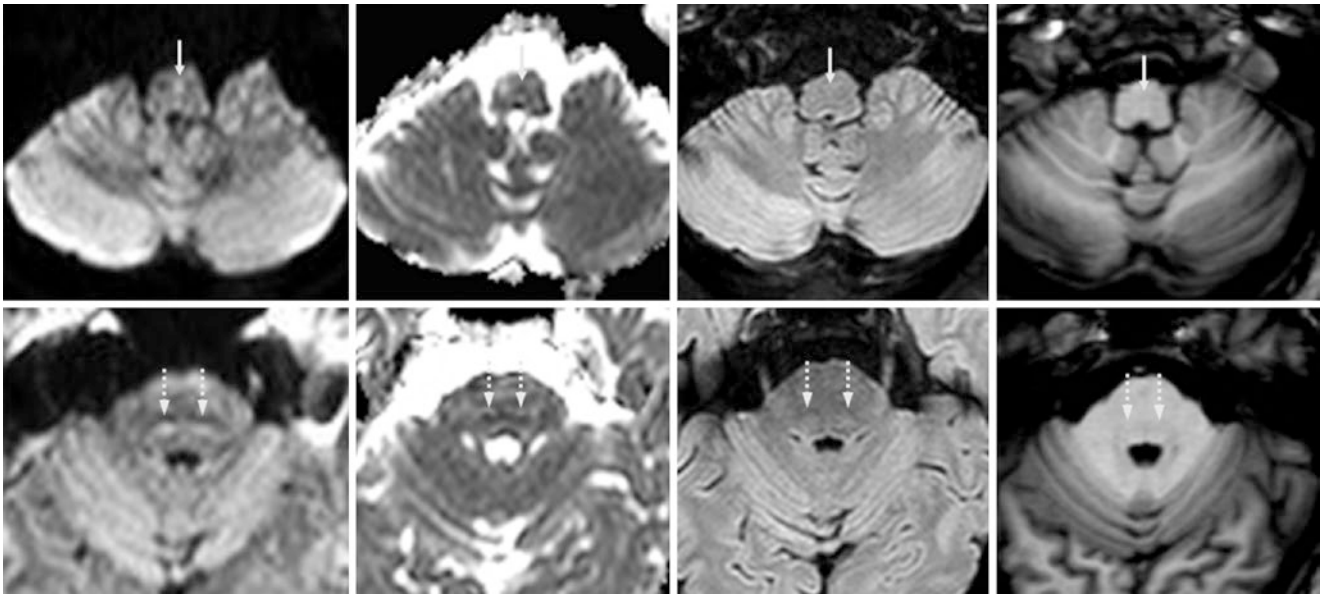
A 38-year-old with a normal 3 T MRI. *Top row:* There is hyperintensity within the pyramidal decussation (*thin arrows*) on DWI (*left*), but no corresponding dark signal on the ADC map (*left middle*); 3D-reformatted FLAIR (*right middle*) and T1WI (*right*) are normal.
